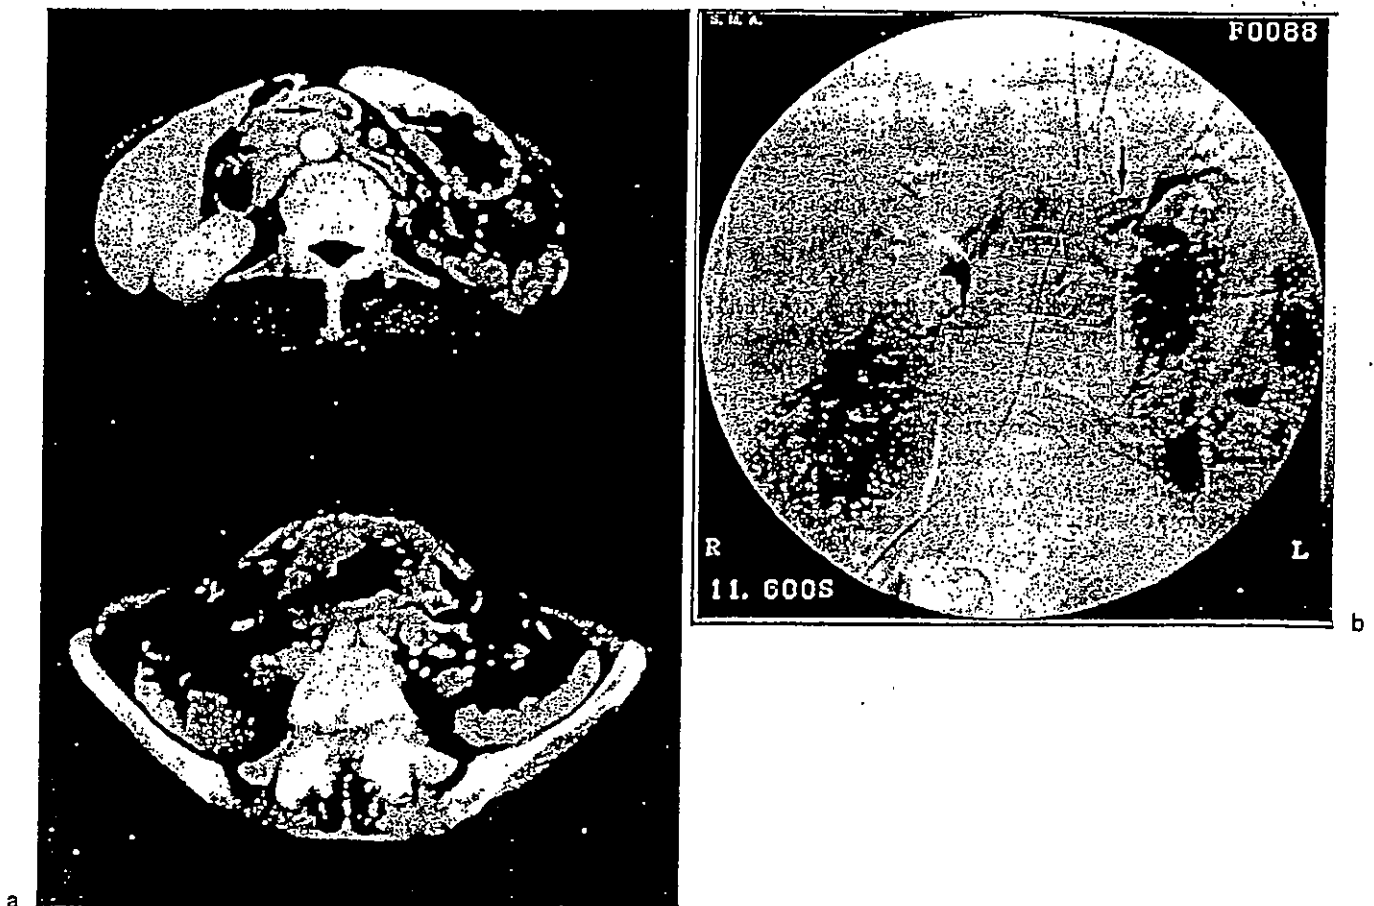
Case 2. a CT scans. *Upper*; the superior mesenteric vein running below the pancreas was occluded by tumor thrombi. *Lower*; large tumor with lumen indicates transverse colon cancer with direct invasion to the stomach. b Abdominal angiography. Late phase of celiac angiography showed that the portal venous flow to the liver was maintained by splenic venous flow. The portal vein tree in the liver was visualized well. *Arrow* indicates the splenic vein
